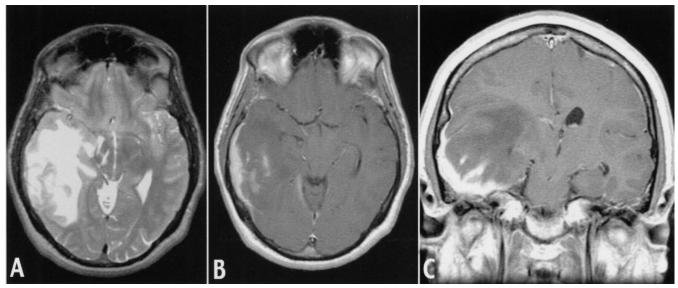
MRI scan prior to treatment. A. Axial T2 weighted image showing vasogenic edema throughout the temporal lobe and into the right cerebral peduncle and midbrain. The third ventricle is shifted across the midline from the mass effect. B. Axial T1 weighted post-contrast scan with dural and pial arachnoid enhancement. The right temporal horn is pushed forward and medially with midbrain compression. C. Coronal T1 weighted post-contrast scan showing pachymeningeal, pial-arachnoid, and parenchymal enhancement (bright high signal) and parenchymal edema (low signal) with subfalcine shift.
